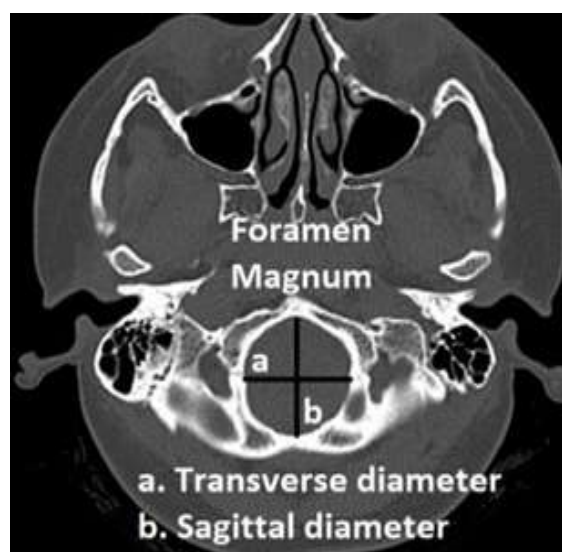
Measuring the anteroposterior and transverse diameter of foramen magnum on CT Images
